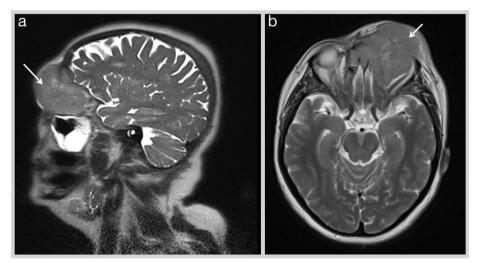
(a) Sagittal view and (b) axial view of MRI head and orbits with contrast demonstrating the left orbital tumour (white arrows) displacing the globe anterolaterally and extending to the paranasal sinuses and left nasal cavity.
